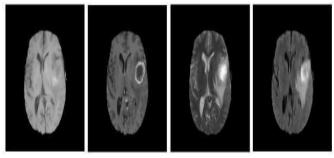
Four MRI scans reveal high-grade gliomas. Tumor burden is found in all quantiles. Begin with T1.
